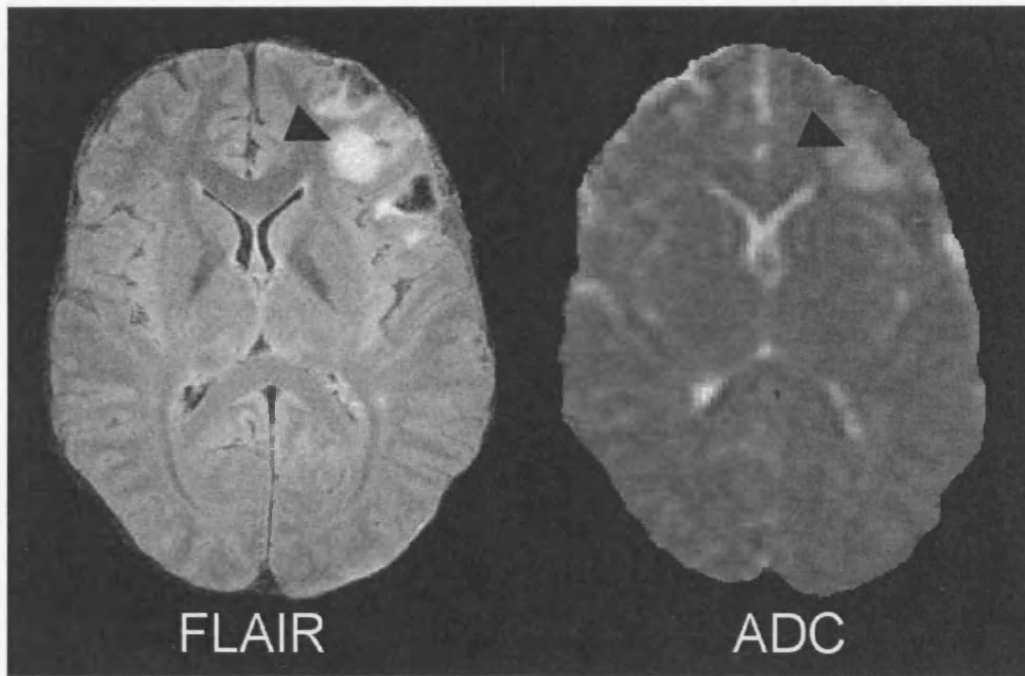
FLAIR hyperintensity associated with increased ADC values.
